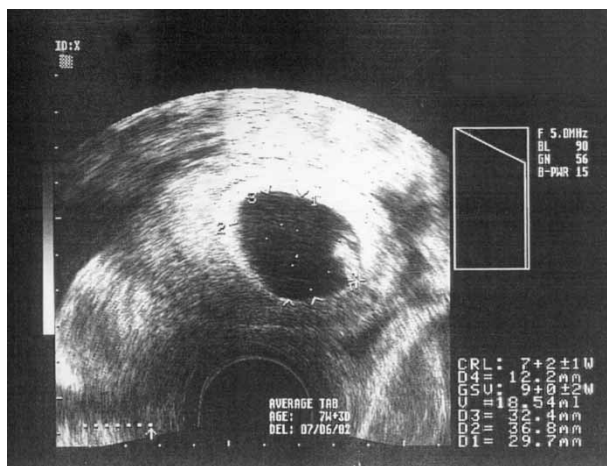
Transvaginal ultrasonography showing 7 weeks' gestation without cardiac activity.
